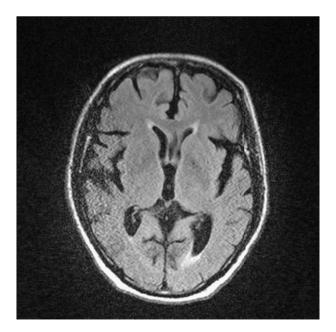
Representative axial fluid-attenuated inversion–recovery MR image showing mild periventricular hyperintensity and diffuse, age-related volume loss.
